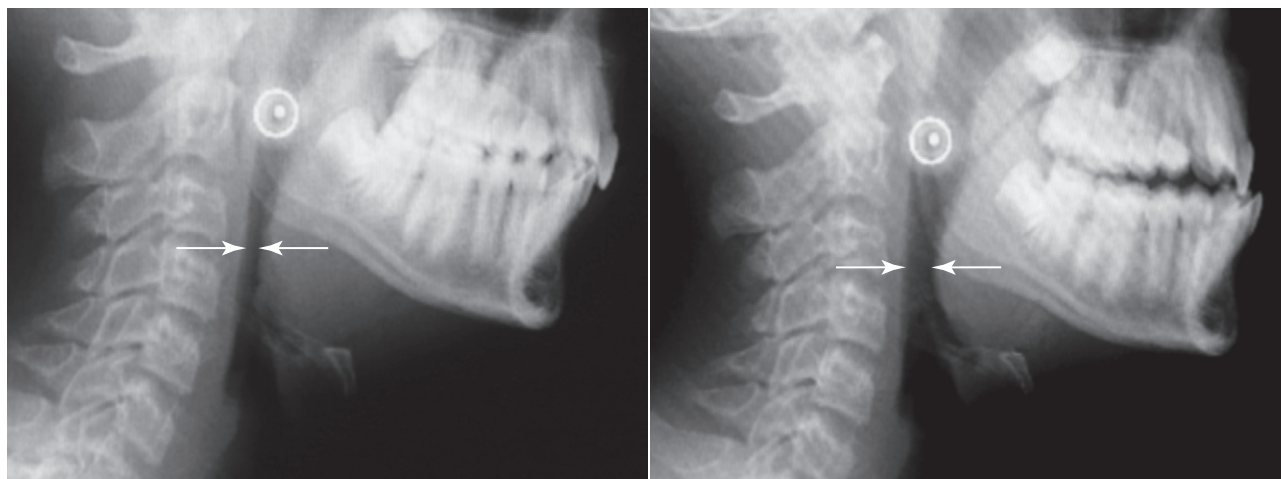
A, Pre-treatment radiograph, overjet 2 mm, small posterior pharyngeal airway. (Angle of mandible.) B, When the mandible was advanced to 3 mm protrusive, the size of the posterior pharyngeal airway doubled.
